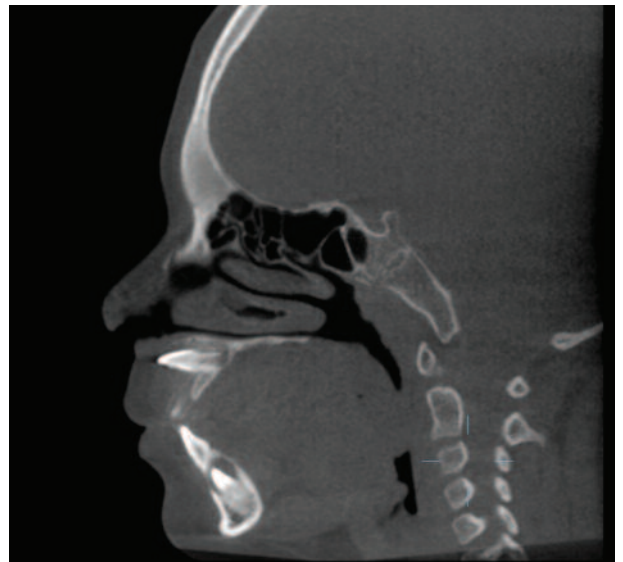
A sagittal view of this tooth shows normal development of the crown and root, but a very unique horizontal impaction. This image and related CBCT images allow for improved surgical planning in comparison to standard digital images.
